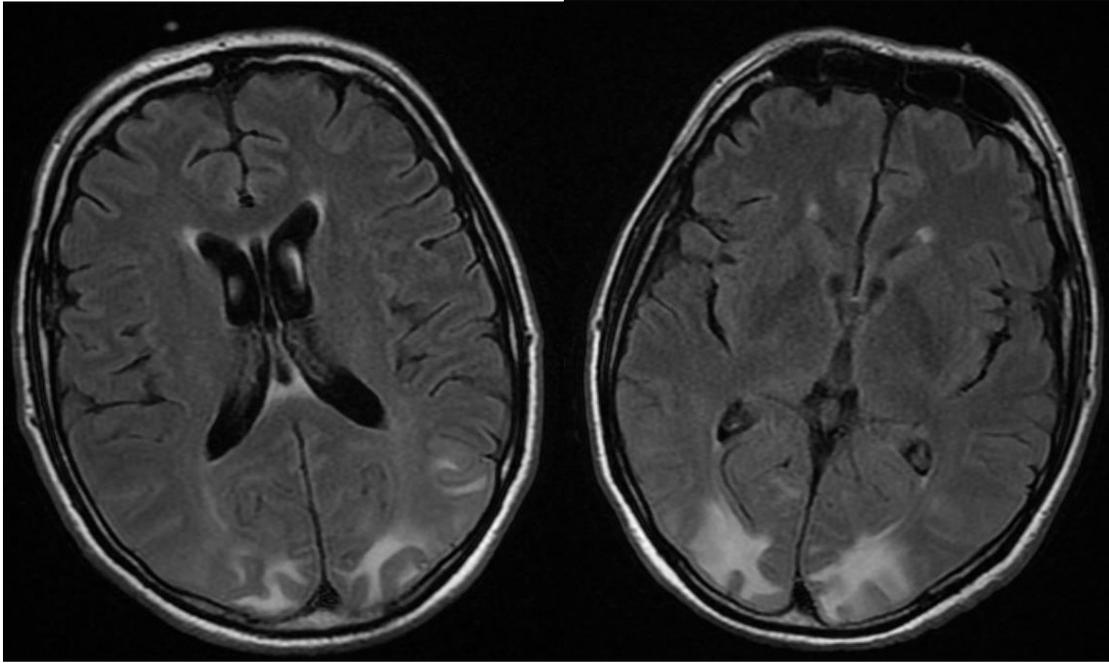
Axial T2 FLAIR showed hyperintensity involving the subcortical white matter of both occipital lobes and posterior temporal lobe on the left, compatible with PRES.
